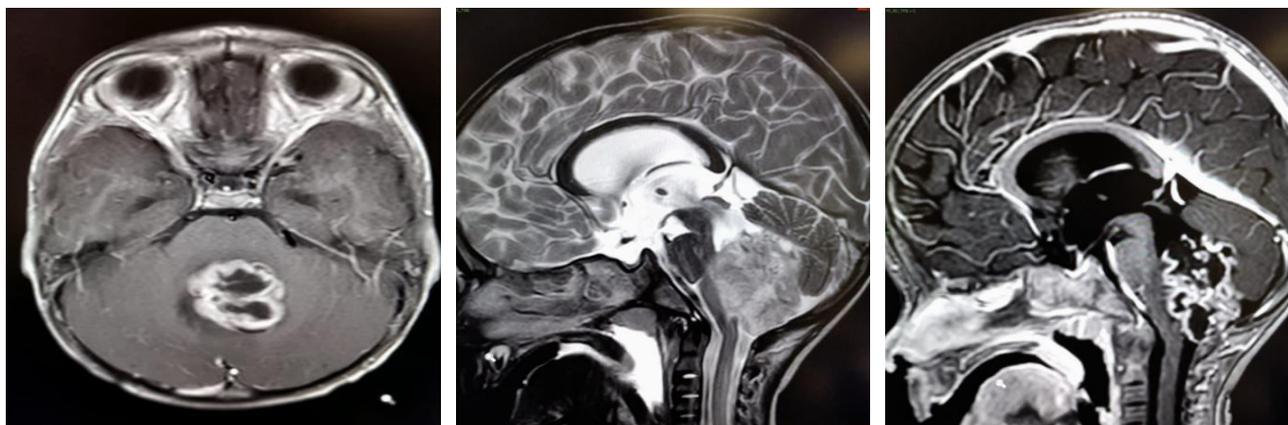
MRI demonstrating midline posterior fossa lesion, hydrocephalus, ependymoma, and fourth ventricle mass compressing brainstem and vermis.
